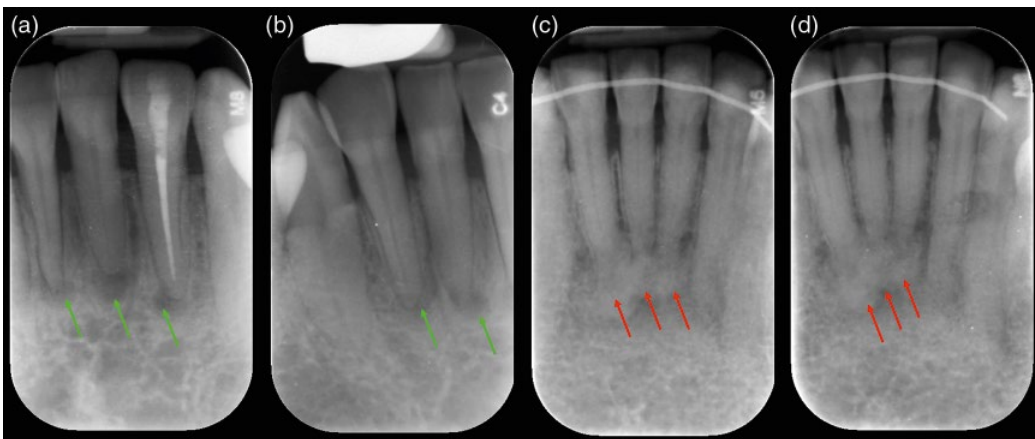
Periapical cemental dysplasia. (a, b) Early stage: well-defined radiolucencies (green arrows) associated with the all the lower incisor teeth. The teeth test vital, but tooth 32 was misdiagnosed to have apical periodontitis and was root treated. (c, d) Intermediate stage: periapical radiographs of the lower incisor region reveals a poorly defined radiolucency with patchy radiopaque inclusions (red arrows) associated with vital lower incisor teeth.
